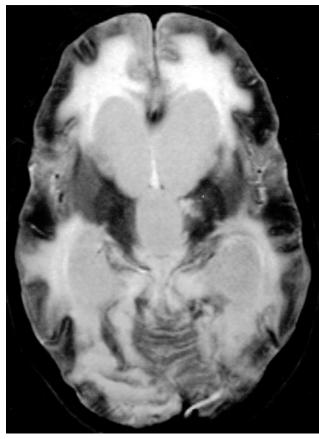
T2-weighted cerebral magnetic resonance imaging shows multiple infarctions in the occipital and thalamic regions and a generalized edema.
